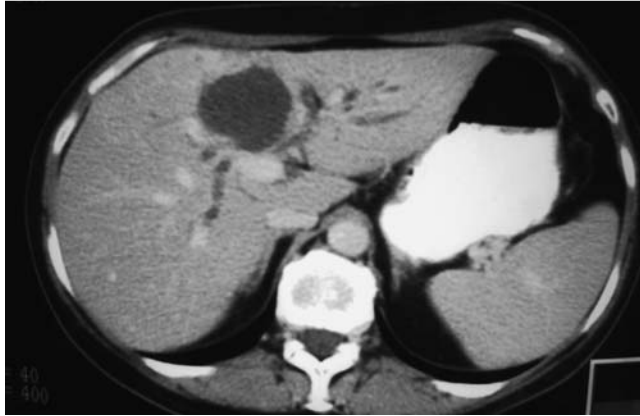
Abdominal computed tomography (CT) image of an echinococcal cyst in the right lobe of the liver.
